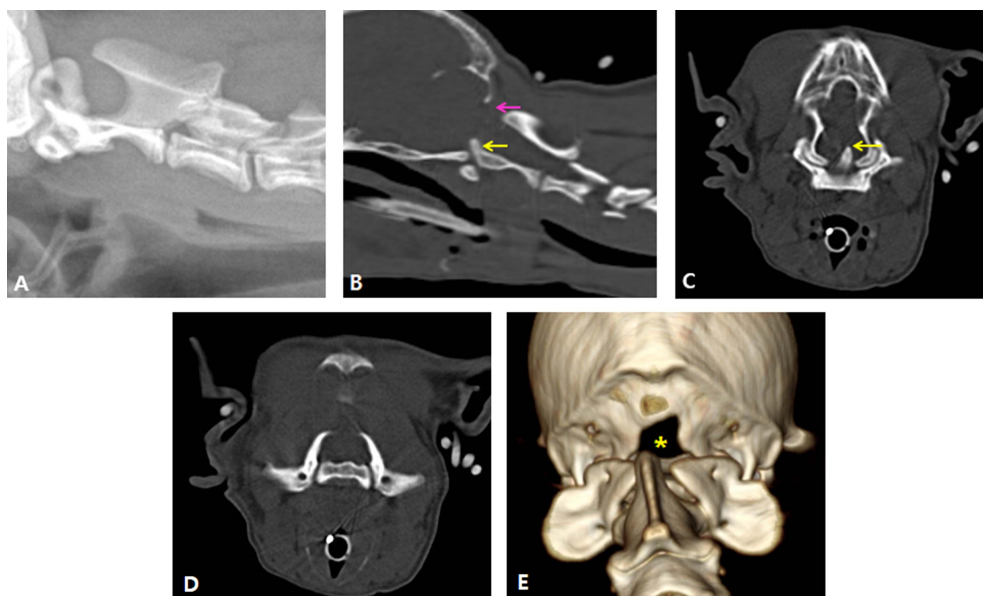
Diagnostic images. Cervical radiograph (A) and sagittal CT image (B). The yellow arrow is pointing to the dorsal angulation of the dens. The purple arrow is pointing to the defect in the dorsal lamina of atlas. The image (C) and (D) is transverse CT view, showing dens dorsal angulation and incomplete ossification of atlas bone each other. The figure (E) is 3D reconstruction image of the CT image. The yellow asterisk is indicating expansion of the foramen magnum.
